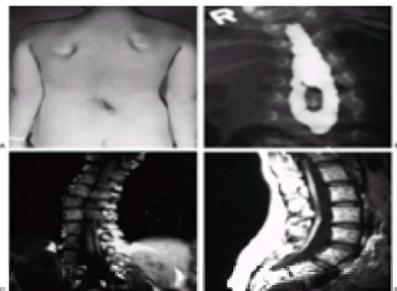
A: This patient presented with right thoracic scoliosis with a prominent right scapula and hair patch in the lumbar area. One foot was smaller than the other, and the ankle reflex was absent on that side. B: A myelogram demonstrates a diastematomyelia. C: Magnetic resonance imaging (MRI) scan also shows a diastematomyelia with a split in the spinal cord. D: On the sagittal MRI the cord extended to the sacral area with a tight filum terminale for each hemicord.
